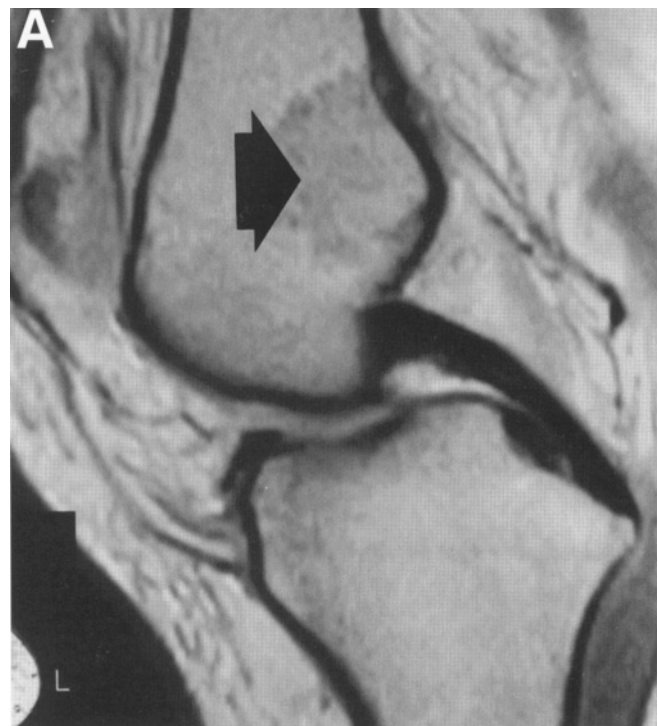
(A) Sagittal and (B) axial MRI of a low-grade chondrosarcoma (arrow) of the posterior aspect of the distal femoral metaphysis. The tumor was approached through the popliteal component of the utilitarian incision.
